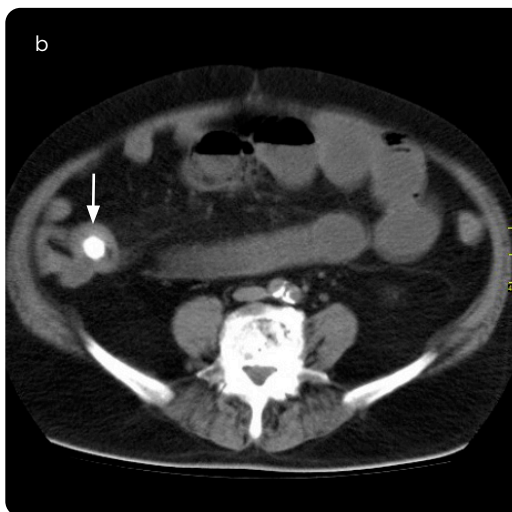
a and b) Simple CT of the abdomen, coronal and axial: Transition zone in the ileocecal valve. High density rounded image is identified, corresponding to biliary calculus.
